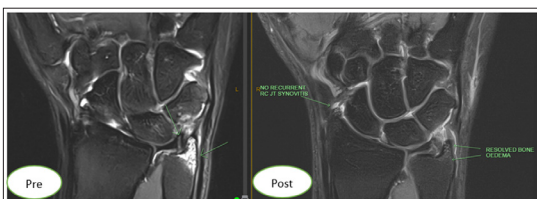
Coronal MRI of the right wrist pre- and post-PRP showing resolution of ulnar styloid bone marrow edema, absence of radiocarpal synovitis or erosions, and healed TFCC
